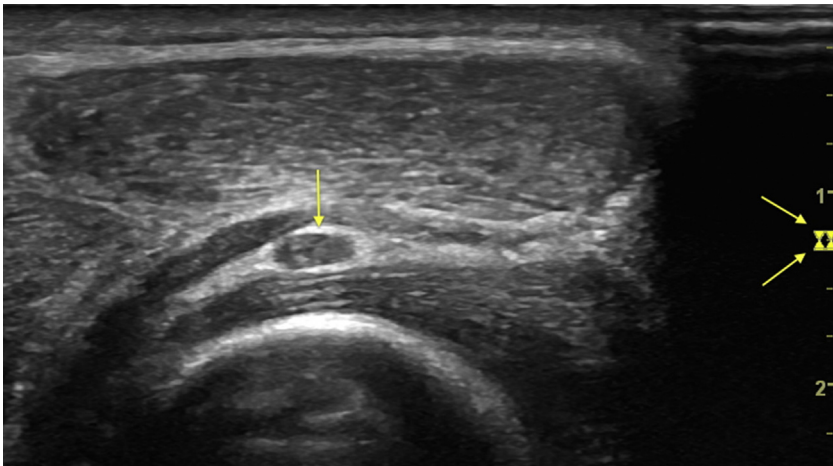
Sonogram demonstrating a short-axis view of an abnormally enlarged deep branch of the radial nerve (*single arrow*) at the level of the supinator. The focal zone (*double arrows*) is set at the appropriate level for optimization of the image.
